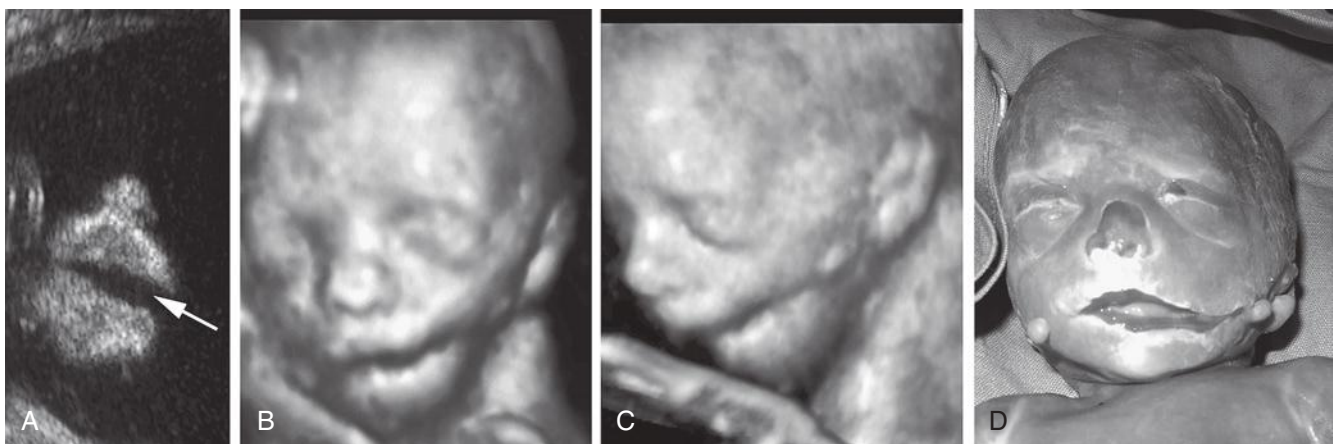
Lateral cleft of the fetal face: A, Anterior coronal scan demonstrating the lips and nose; asymmetry in the shape of the mouth is noted (*arrow*). B and C, Three-dimensional ultrasound surface mode demonstrates a lateral cleft associated with a typically sunken cheek and a skin tag. D, Postnatal image.
